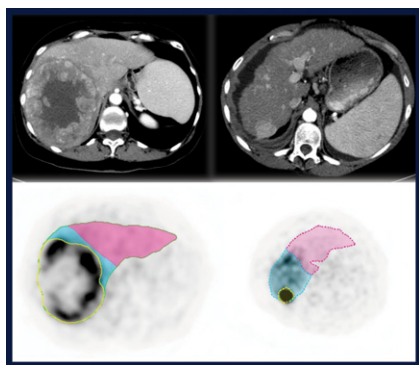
PET/CT dosimetric mapping of ^{90}Y thera-sphere distribution after radioembolization for hepatocellular cancer. Left: ^{90}Y PET/CT acquired in patient after radioembolization (top) and dosimetric map (bottom) indicating a dose of 132 Gy to the lesion and 34 Gy to parenchyma.
